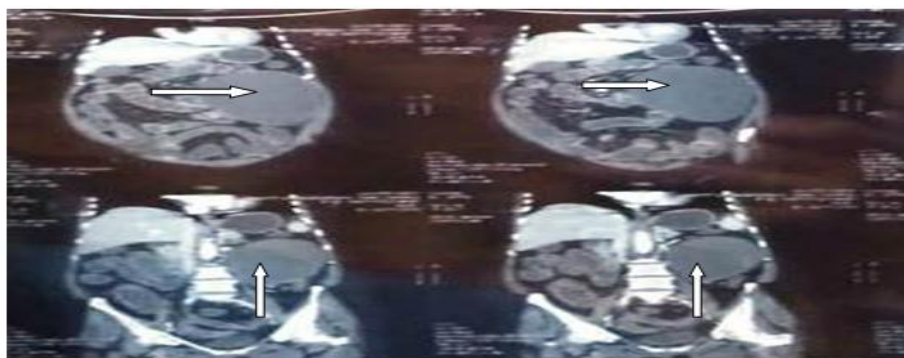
(Sagittal view) CT evaluation suggestive of large peripherally enhancing ill-defined hypo-dense lesion of size 13×14×15 cm reaching up to spleno-renal region superiorly and inferiorly up to left iliac region with no definite organ of origin.
